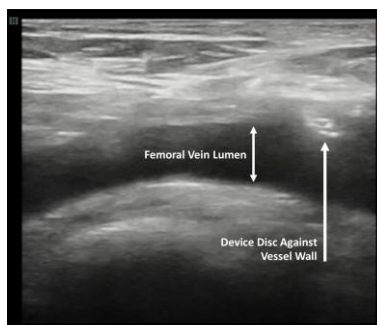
Ultrasound image demonstrating proper position of Disc
